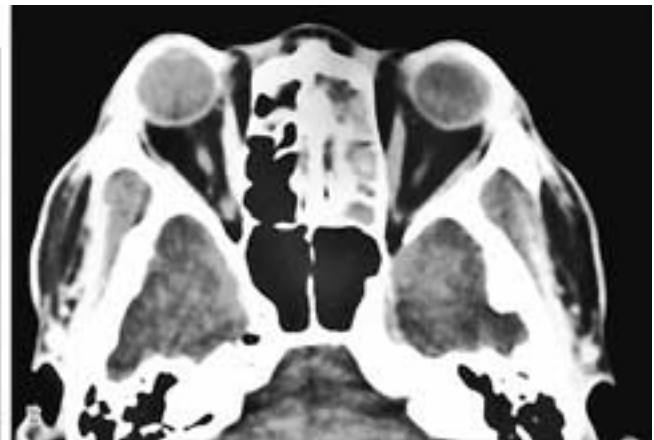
Axial T1-weighted MR image (A) shows presumed inflammatory disease in the left ethmoid complex with apparent aeration of some middle ethmoid cells. However, the axial CT scan (B) shows total opacification of the left ethmoid sinuses. At surgery, the middle ethmoid cells were found to contain aspergilloma. This patient has aspergillosis.
